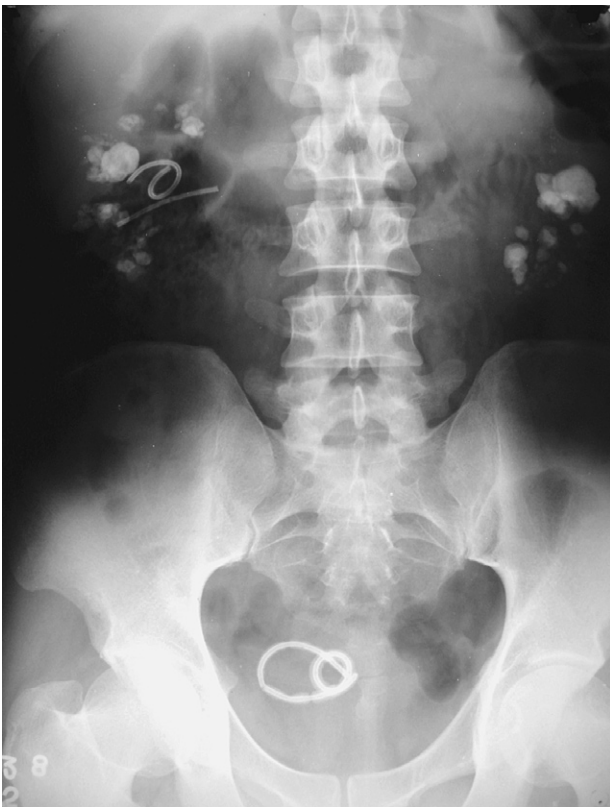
Plain abdominal radiography of the patient showed fragmented pieces of the stent in the bladder and the right pyelocaliceal system.
